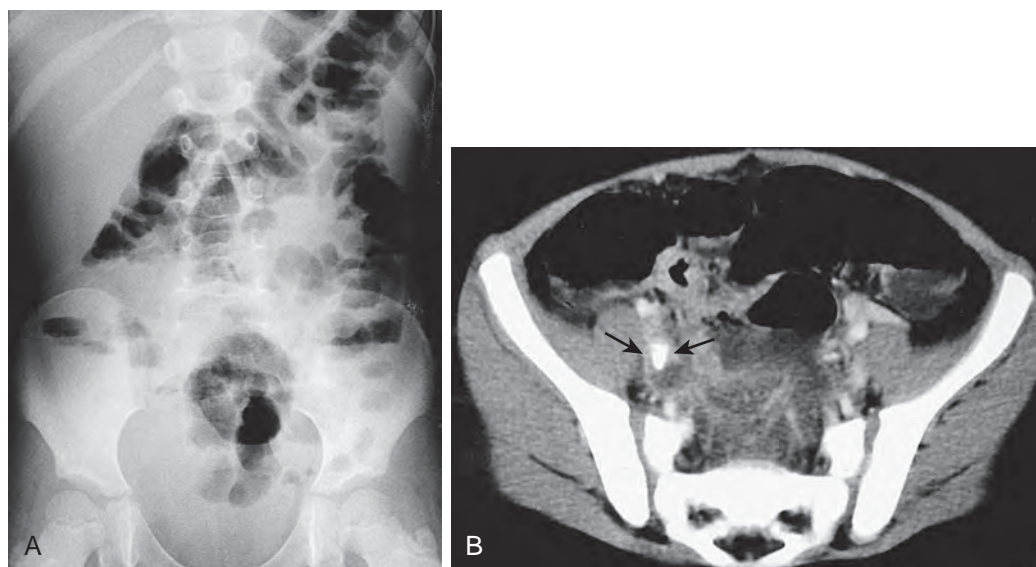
Appendicitis: abdomen radiograph and CT. A. Abdomen radiograph demonstrates a mild left lumbar scoliosis due to right psoas spasm. Several air-fluid levels are present in the lower quadrant bowel loops, a sign of focal ileus. B. CT demonstrates an appendicolith (arrows) in the dilated appendix.
